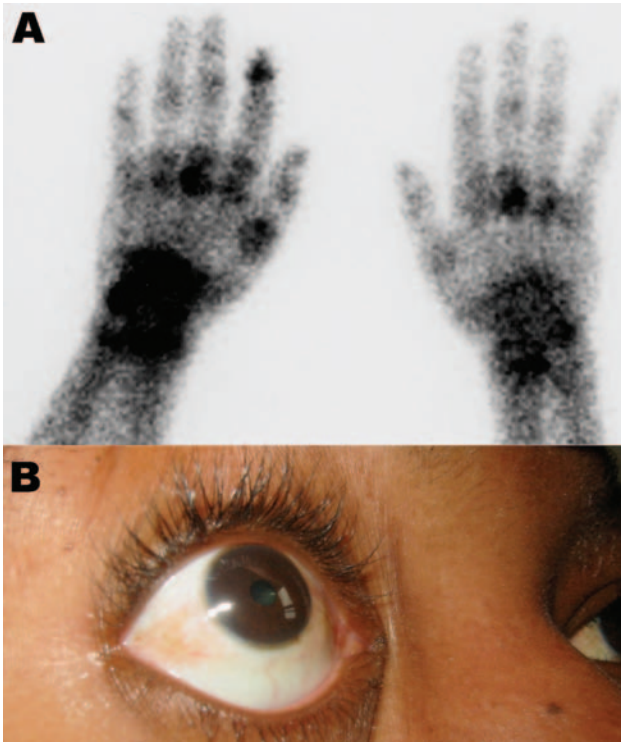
Clinical findings in patients. A) Bone scintigraphy of the wrists and hands showing an intense focus of technetium-99m-labeled methylene diphosphonate tracer uptake, particularly on the left side in the left metacarpophalangeal, wrist, and the first distal interphalangeal joints in a 73-year-old man who returned from Reunion with a severe viremic chikungunya virus (CHIKV) infection. B) Conjunctivitis in a 31-year-old woman who returned from Mayotte, French Comoros, with a severe viremic CHIKV infection.
